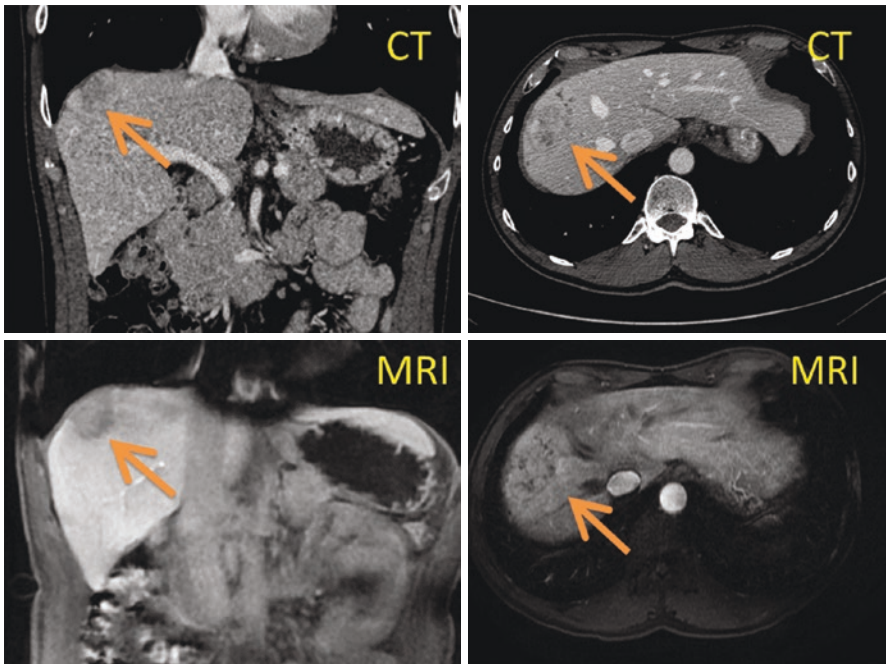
CT and MRI imaging of intrahepatic (S8) CCA
